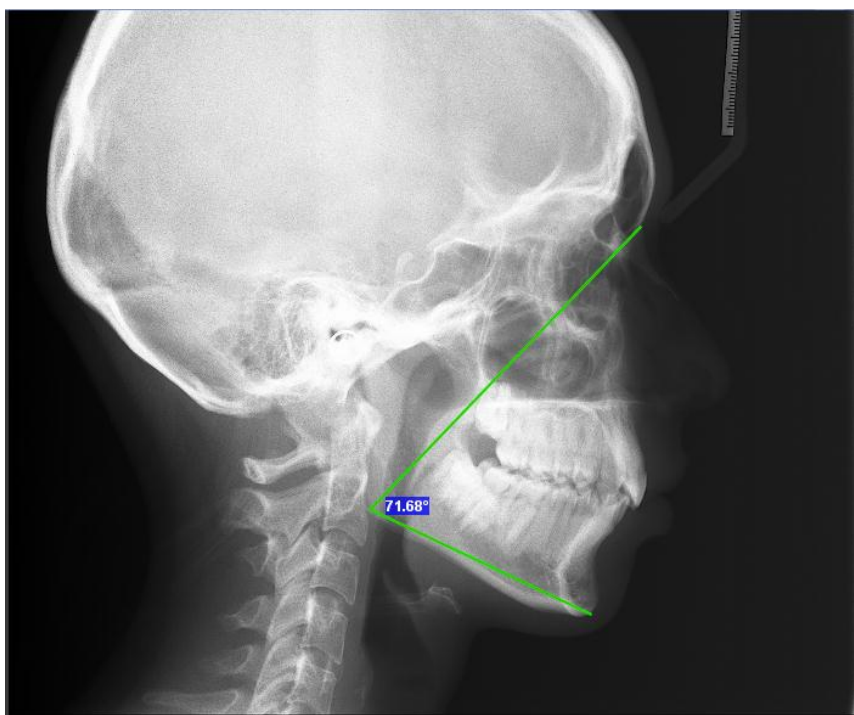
Lateral cephalometric radiograph showing the measurement of $\angle N\text{-Go-Gn}$
